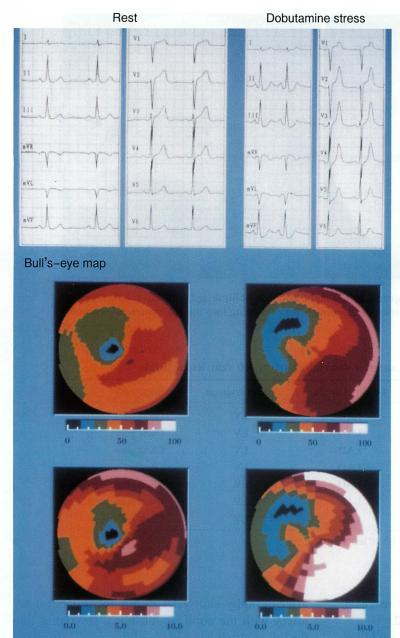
Dobutamine ($12 \mu g/kg/min$) stress technetium-99 tetrofosmin scintigrams showing development of anteroseptal hypokinesis, *i.e.*, depressed regional ejection fraction (*middle row*) and wall motion (*lower row*) with 0.1 mV ST-segment depression in the II, III, aVF, V₅, and V₆ (*upper row*).
